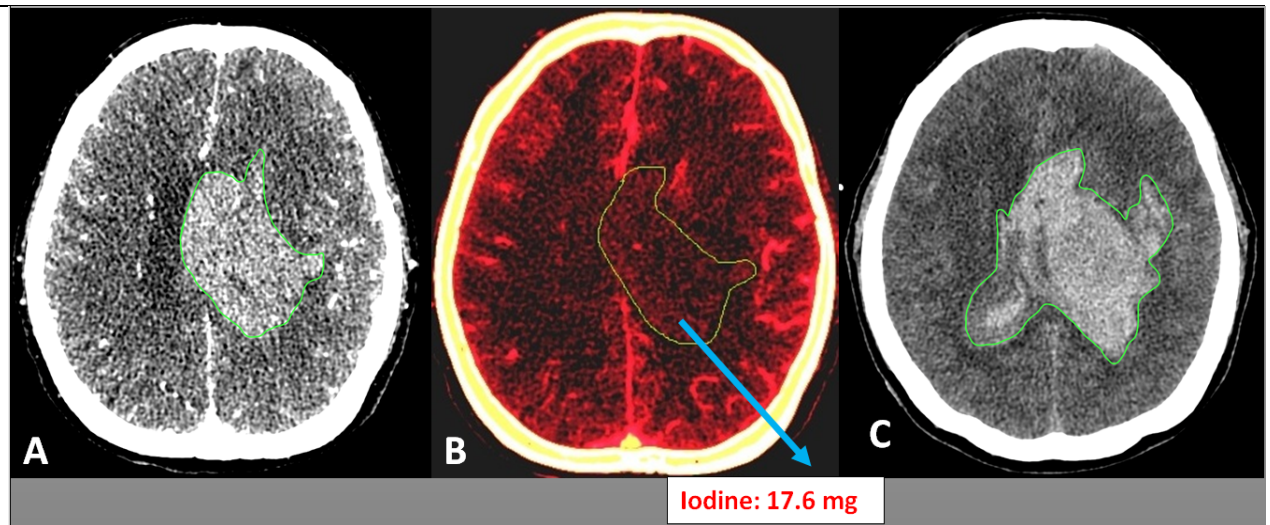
Higher iodine concentration (17.6 mg) on delayed DECT images (B) and hematoma expansion on subsequent CT exam (C)
